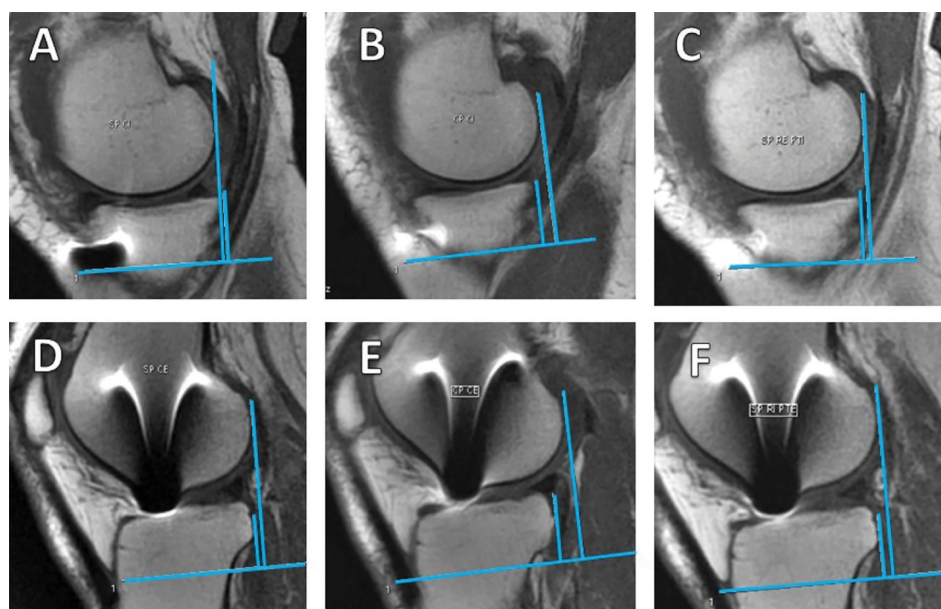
MRI measurements of a PKTD assessment from a patient with an ACL-reconstructed knee. (a) medial plateau, no stress (1 mm); (b) medial plateau PA stress (4 mm); (c) medial plateau, maximum external rotation (2 mm); (d) lateral plateau, no stress (2 mm); (e) lateral plateau PA stress (7 mm); (f) lateral plateau, maximum internal rotation (6 mm).
